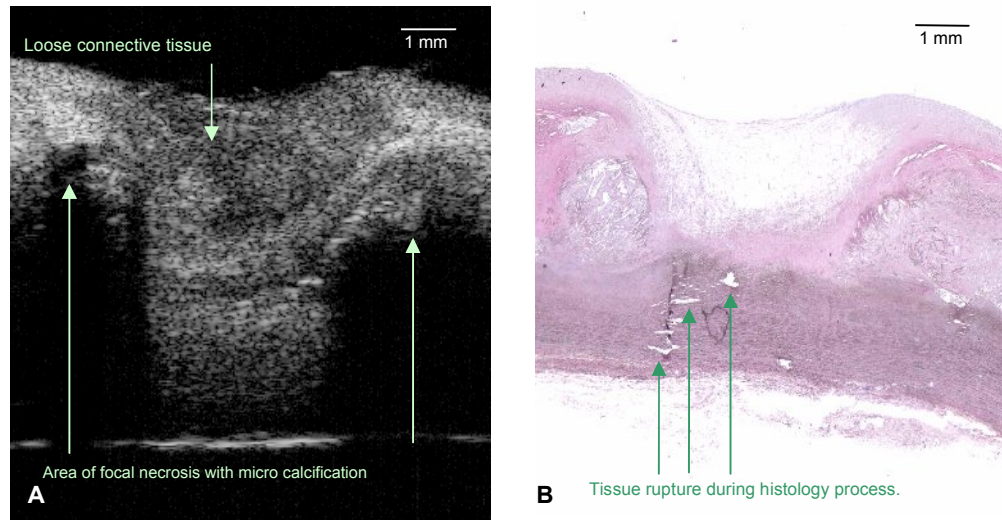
Ultrasonic image of a cadaveric aorta from a 2 mm aperture transducer.
